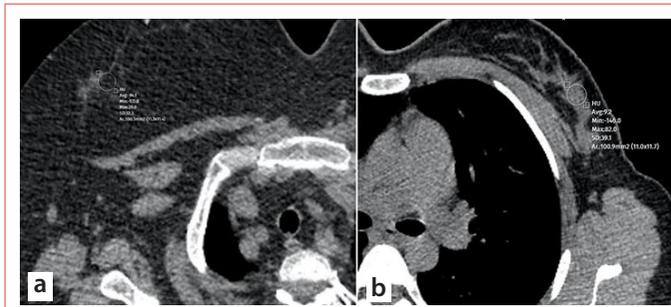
Representative axial chest computed tomography (CT) images demonstrating CT attenuation (hounsfield unit) measurements. These images show the location and technique of attenuation measurement corresponding to the regions where ultrasonographic imaging and stiffness assessment were performed in the same patients. The measurements were obtained from the parenchymal areas within the regions of interest, indicated by thin white circles. The image on the left (a) belongs to a 57-year-old female patient, with the measurement obtained from the upper outer quadrant of the right breast, while the image on the right (b) belongs to a 42-year-old female patient, with the measurement obtained from the upper outer quadrant of the left breast.
